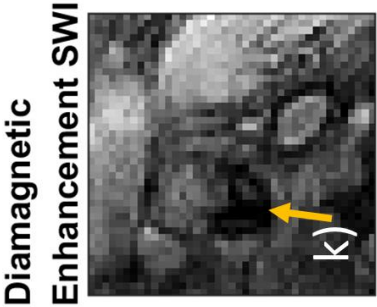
Pre- (a-d, f-j) and post-contrast images (k-s) from the multi-contrast protocol. On the pre-contrast images calcification is identified by a positive phase shift on the filtered phase images of both bright (c) and black blood (d) gradient echo images as indicated by the yellow arrows. The signal in this region was selectively suppressed on the SWI specifically used to detect diamagnetic materials (a) but not on the SWI used for detection of paramagnetic materials (b). Correspondingly, calcification appeared as hypointense on the  $T_2^*$ w bright (f) and black blood (g) images, 3D TOF (i) and  $T_1$ w CUBE (j). It furthermore led to hyperintensities on  $R_2^*$  maps (h) and CT (e). USPIO-contrast agent uptake rendered the signal in the post-contrast filtered phase images (m, n) inhomogeneous (red arrow). The plaques appeared hypointense on all the other contrast weightings and exhibited a high  $R_2^*$  value.
